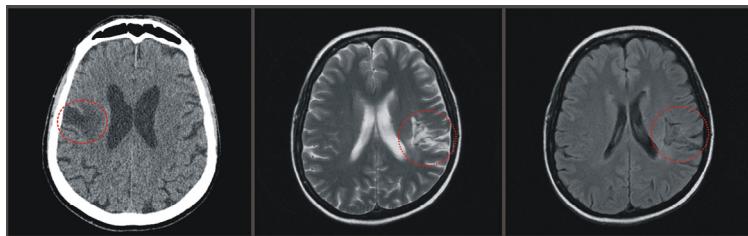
Example challenging identification tasks in brain images. The areas inside the red circles are the areas to be identified. Due to the aforementioned problems, the identification of some tissues in medical images can be difficult even in modalities with high resolution as CT (left image) and MR (middle and right) (images acquired at the Imaging Department - Heart Institute – HCFMUSP- with patient anonymization).
